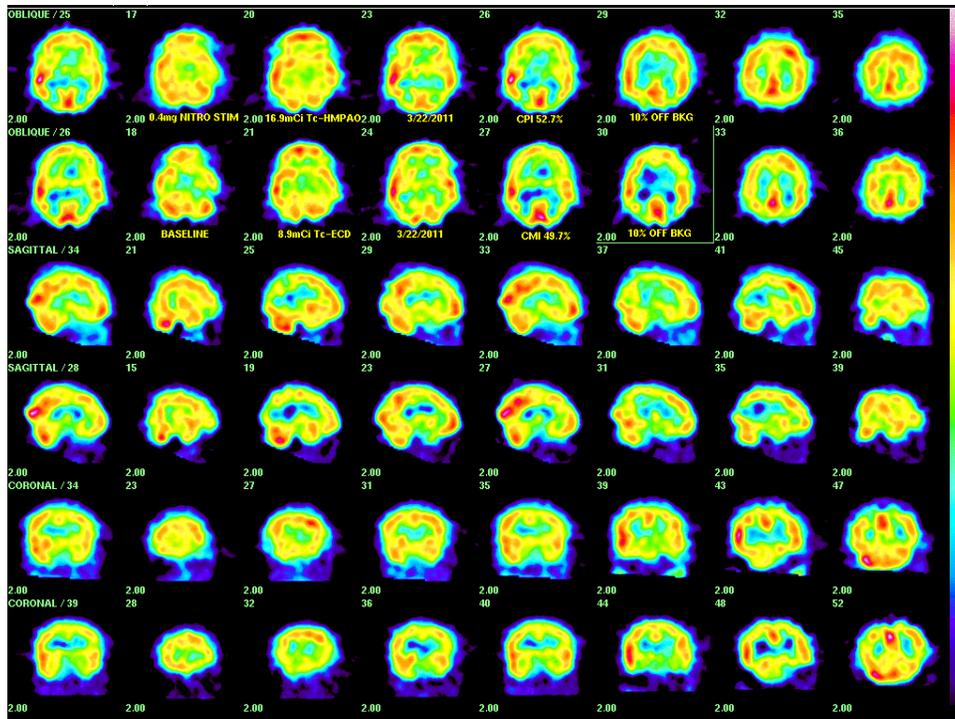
(above) The same, now 46 year-old woman whose brain SPECT was shown above (Fig. 6a) is involved in a more serious motor vehicle accident (combined impact speed > 50 miles/hr) and although she does not recall losing consciousness, suffers acceleration-deceleration traumatic brain injury (TBI) accompanied by a post concussion syndrome, with exacerbation of migraine headache, difficulty concentrating and lightheadedness. She also has even more difficulty with controlling her weight and often gains several pounds within a week. Although TBI patients often show abnormality more prominently in perfusion-stimulated brain SPECT, this patient's basal study (bottom row of 3 paired image rows to the right) shows more prominent basal ganglia abnormality, patchy temporal deficits, bilateral posterior parietal and patchy periventricular hypoperfusion. Her renal function at the time of the follow-up study is normal. Use of Tc-99m-ECD, which more closely mirrors F-18 fludoxyglucose determined cerebral metabolism, for the follow-up basal study may also have enhanced recognition of subtle metabolic abnormalities. Initial evaluation of pituitary function in this patient was normal, although in the present series of patients with neurological complaints, 46/107 or 43.0% of TBI patients had at least one abnormal (inappropriate) pituitary hormone level.
